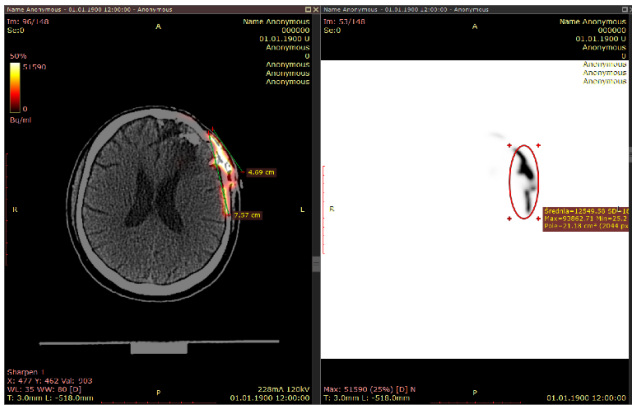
CT scan with corresponding PET scan. On the left side, there is a fusion of two brain images presented.
